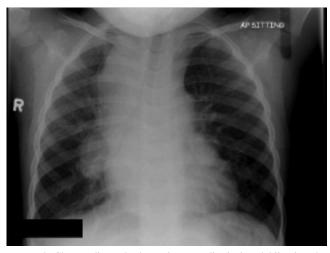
Chest radiograph shows large mediastinal and hilar lymphadenopathy.
